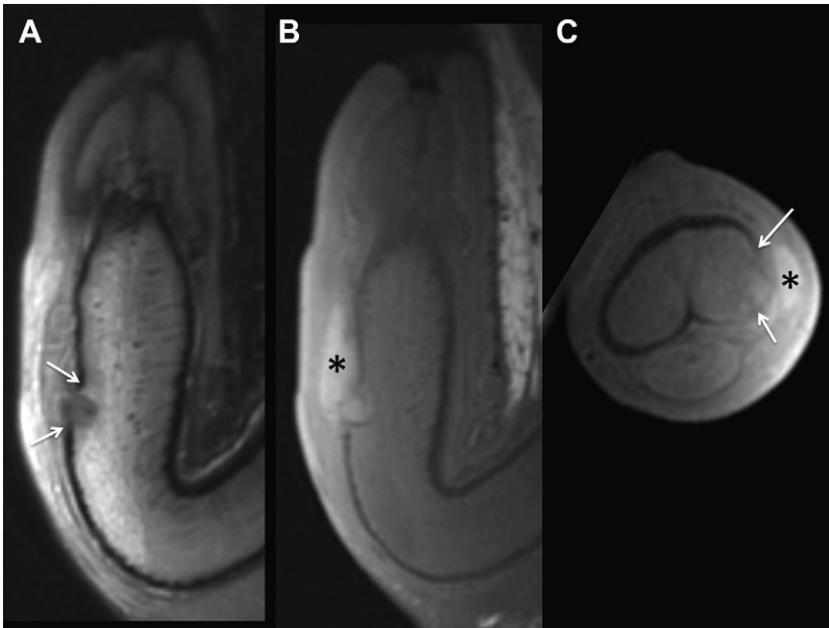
MR imaging of penile fracture. (A) Sagittal T2-weighted image demonstrates focal interruption of the tunica albuginea consistent with tunica albuginea rupture (arrows). (B) T1-weighted image demonstrates high signal blood products in the overlying Buck fascia (asterisk). (C) Axial T1-weighted image demonstrates fracture of the cavernosum with discontinuity of the T1-weighted hypointense tunica albuginea on the left lateral side (arrows). High-signal overlying hematoma is again seen (black asterisk).
